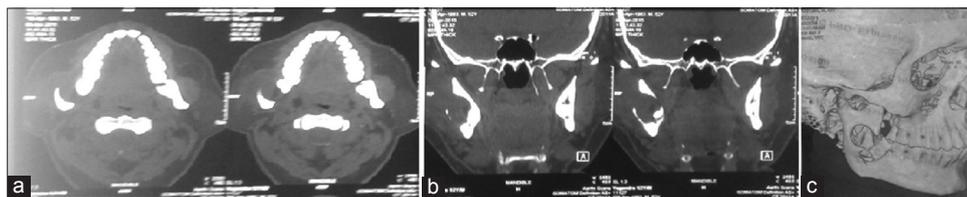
(a) Axial section of computed tomography (CT) showing perforation of buccal and lingual cortical plates, (b) coronal section of CT showing expansion of both the cortical plates of ramus, (c) 3D CT showing cortical perforation of ramus
